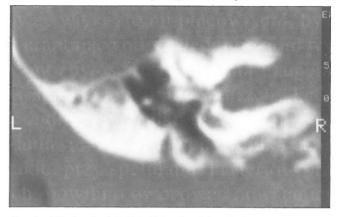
CT of patient K. it is determined the displacement of the III part of a facial nerve channel in front
